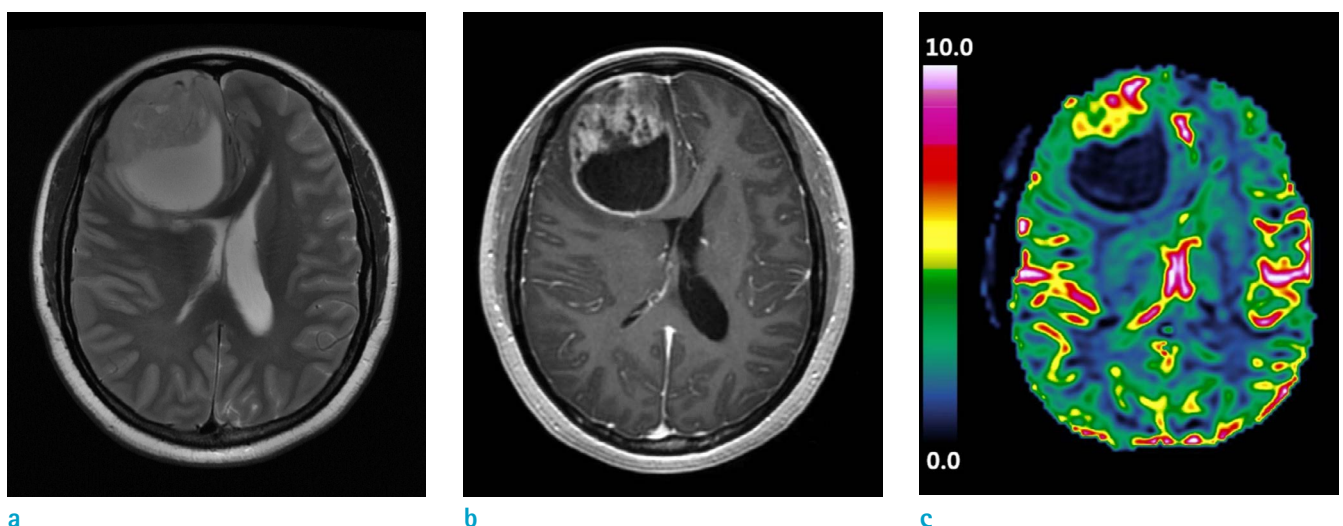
A 43-year-old female with glioblastoma in the right frontal lobe. (a) T2-weighted image, (b) T1-weighted contrast-enhanced image, and (c) rCBV map are shown. The mean rCBV value measured from the enhanced part of the tumor was 3.48. The molecular analysis revealed that both MGMT promoter and 1p19q were intact. The overall survival was 106 months.
